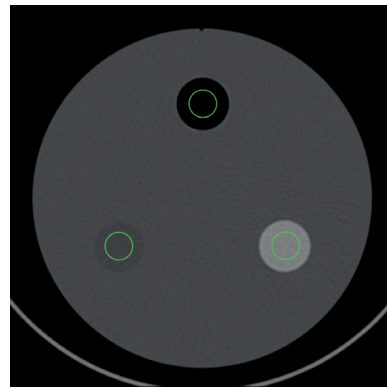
CT Image showing CT Value analysis
